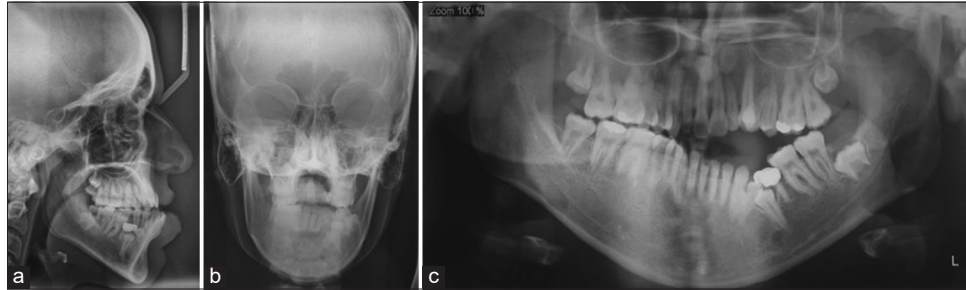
(a) Pretreatment lateral cephalometry. (b) Pretreatment posteroanterior cephalometry. (c) Pretreatment panoramic radiograph.
